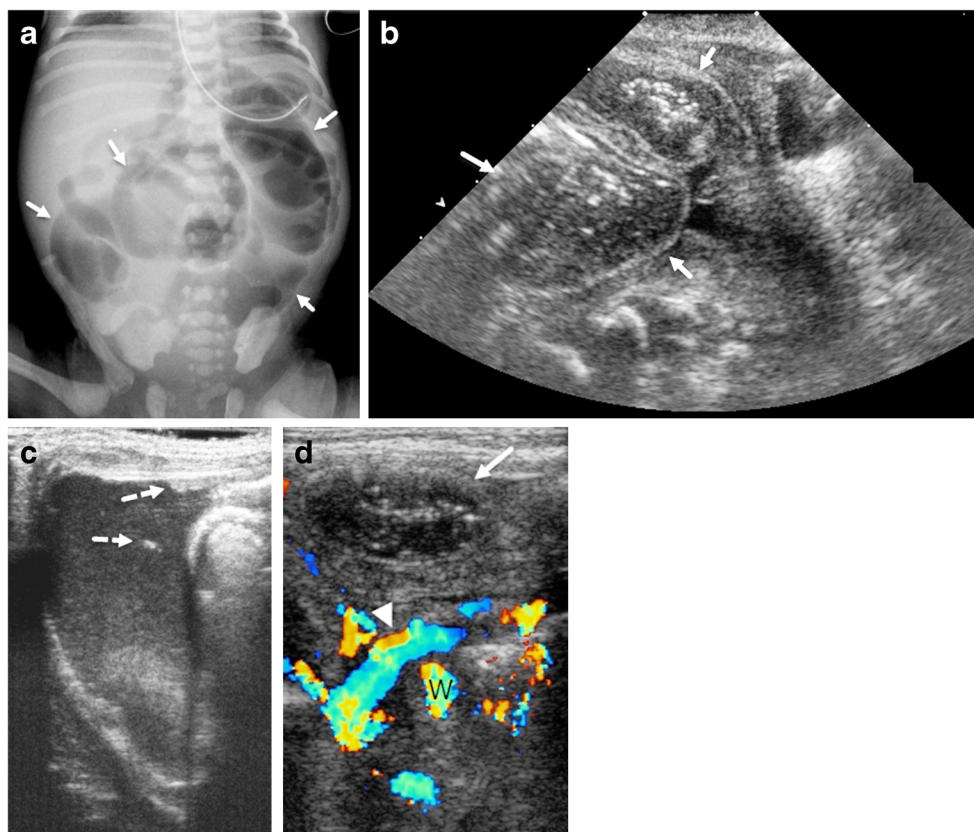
Small-bowel obstruction in a term boy with a fetal diagnosis of meconium peritonitis (gestational age 36 weeks). a Anteroposterior supine portable radiograph of the abdomen obtained at 1 day old shows multiple dilated small-bowel loops (*arrows*), in keeping with distal small-bowel obstruction. No calcifications are identified. b, c Transverse ultrasound images of the abdomen performed at 2 days old demonstrate (b) dilatation of small-bowel loops (*solid arrows*) with (c) ascites between
